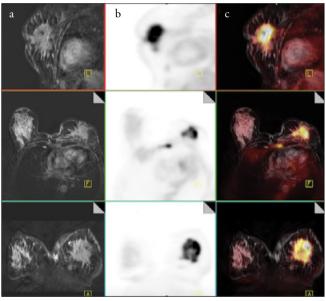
a-c. Irregularly bordered mass lesion with 18F-FDG involvement connected to heterogeneous-enhanced high metabolic activity and sternum metastasis in the retroareolar area of the left breast in the fat-suppressed postcontrast (a), PET (b), and PET/MRI fusion images (c)
